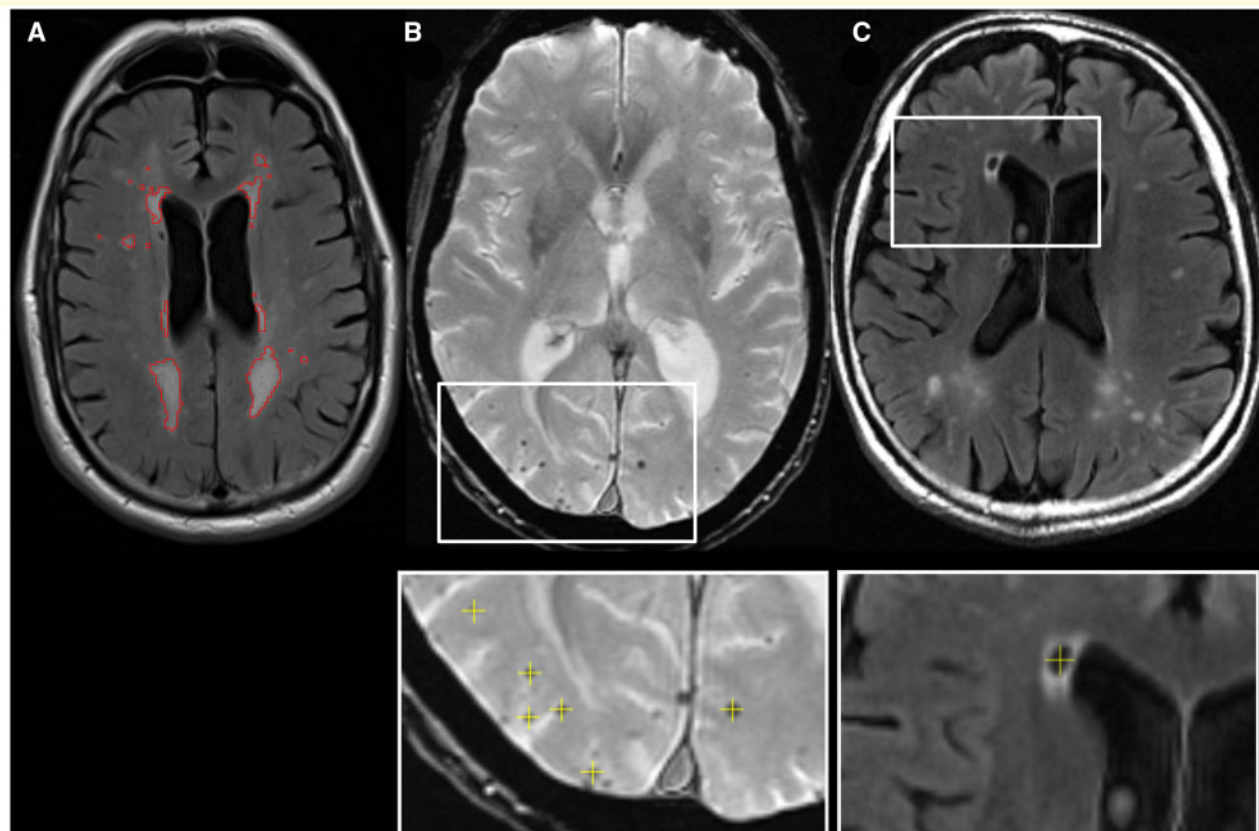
Small vessel disease markers. Axial views of A white matter hyperintensity (outlined in red) on a FLAIR image; B Cerebral microbleeds unlabelled with labelling shown underneath (yellow crosses) on a T_2^* image; C a lacune with labelling shown underneath (yellow cross) on a FLAIR image.
